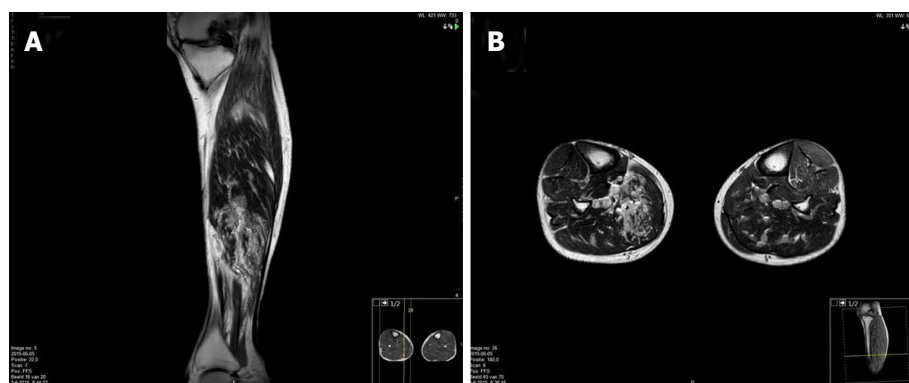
Magnetic resonance imaging of both legs. A: Sagittal plane magnetic resonance imaging (MRI) of both legs reveals bilateral multiple saccular intramuscular venous malformations involving the musculus soleus; B: Transverse plane MRI of both legs reveals bilateral multiple saccular intramuscular venous malformations involving the musculus soleus.
